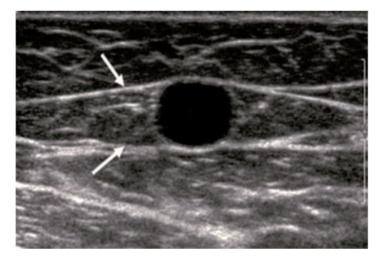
Ultrasound image of the saphenous compartment.
